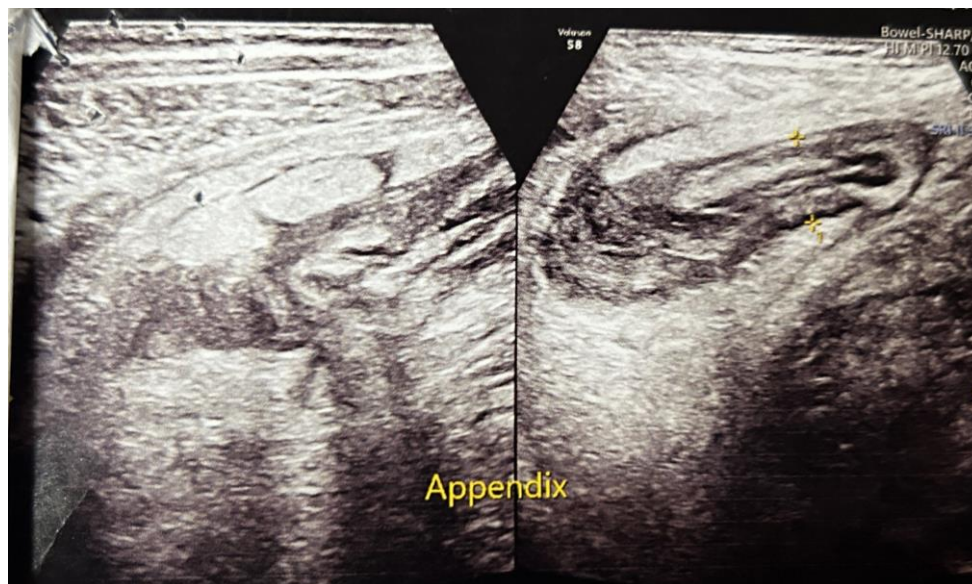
Ultrasound showing distended appendix with surrounding fat stranding.
